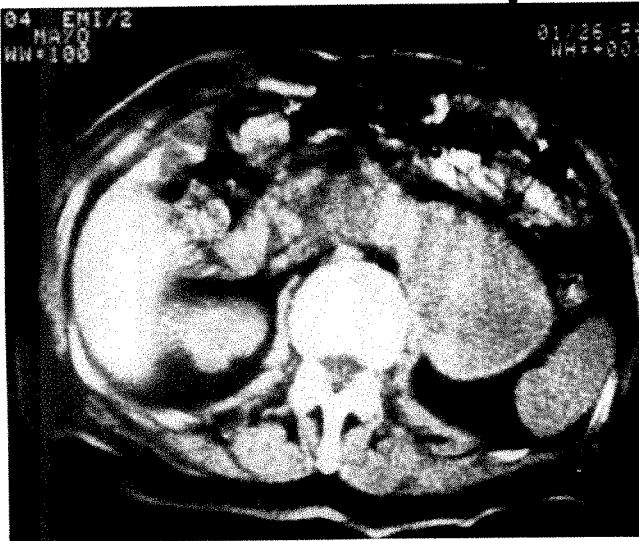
CT scan of 81-year-old man with hematuria. Excretory urogram showed 10 cm mass projected over upper pole of left kidney (thought possibly due to adrenal tumor). Enlarged, sharply circumscribed mass in left parasagittal region likely arises from abdominal aorta which is not clearly outlined. Angiogram confirmed large secular aneurysm of abdominal aorta.
